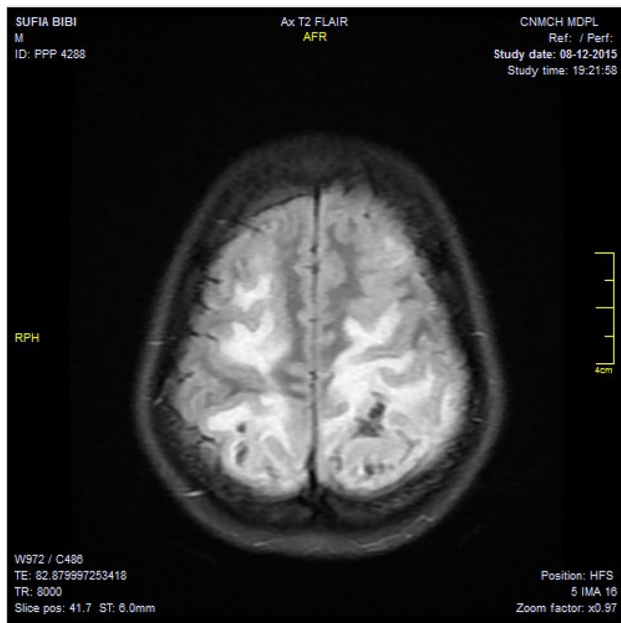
MRI of the brain, axial view—extensive areas of vasogenic edema (diffuse hypo-dense areas) in the region of parietal, occipital, frontal and temporal lobes of the brain
